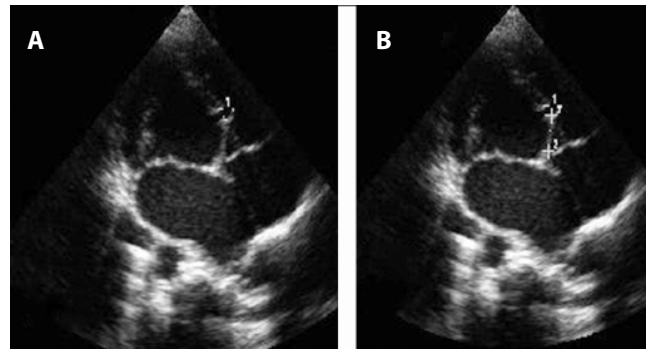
Transthoracic Echocardiography. Four chamber view demonstrated a 4 mm muscular ventricular septal defect (A); the distance between the superior rim of ventricular septal defect and AV valves was 11,4 mm (B).
